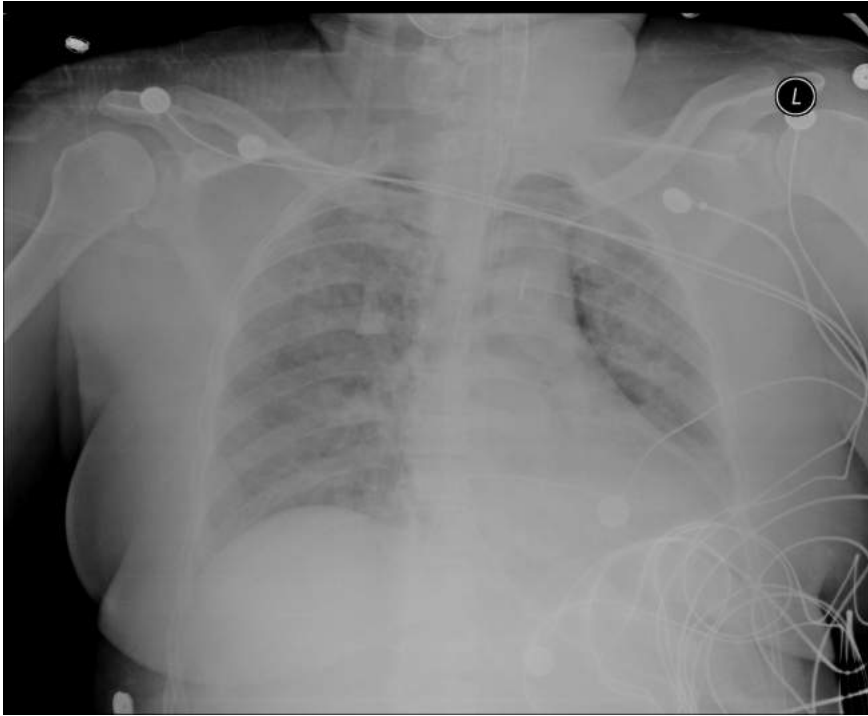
Acute respiratory distress syndrome progressing with increased alveolar filling and atelectasis, 10 hours after the radiograph in Figure 28.
